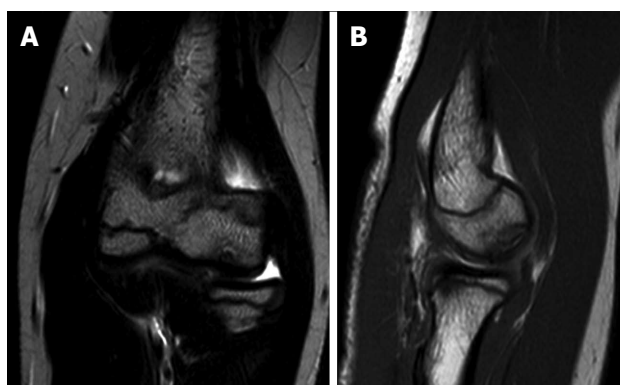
Magnetic resonance images of an elbow affected with osteochondritis dissecans of the capitellum. A: Coronal view; B: Sagittal view.
